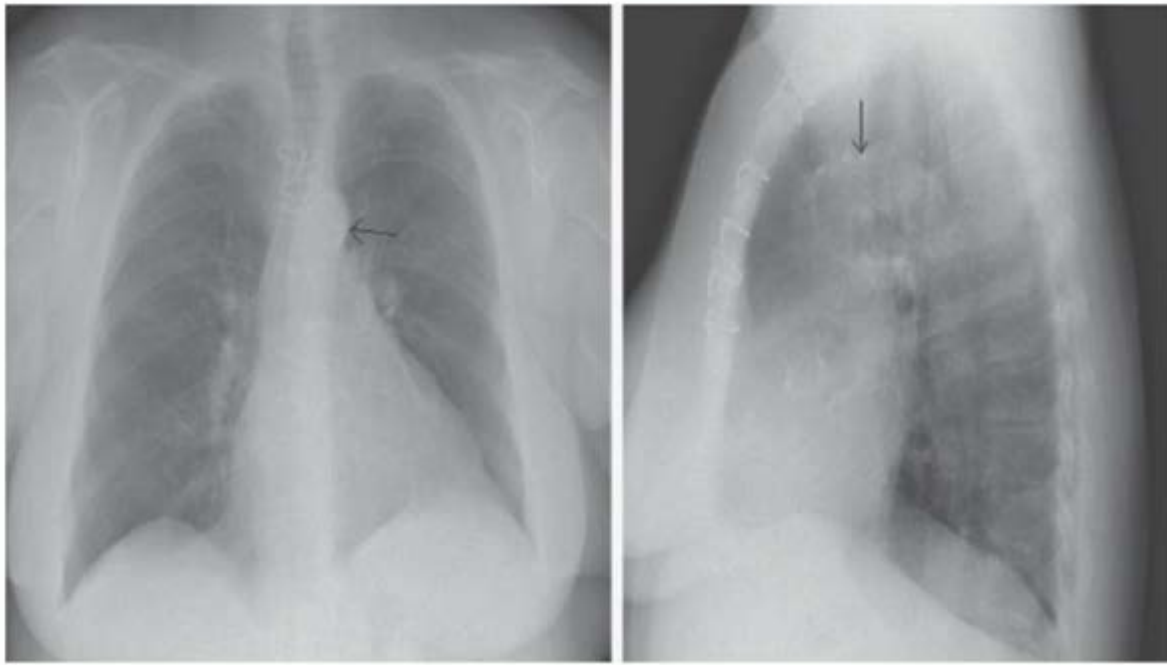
AP (left) and lateral (right) chest x-ray demonstrating a calcified aorta (*black arrows*).
